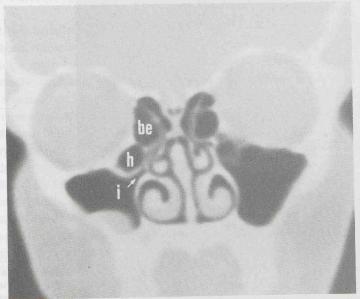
Coronal CT-scan of the sinuses through ethmoidal bulla (be) and ethmoidal infundibulum (i), narrowed by a Haller's cell (h) on the right (side of the patient).
